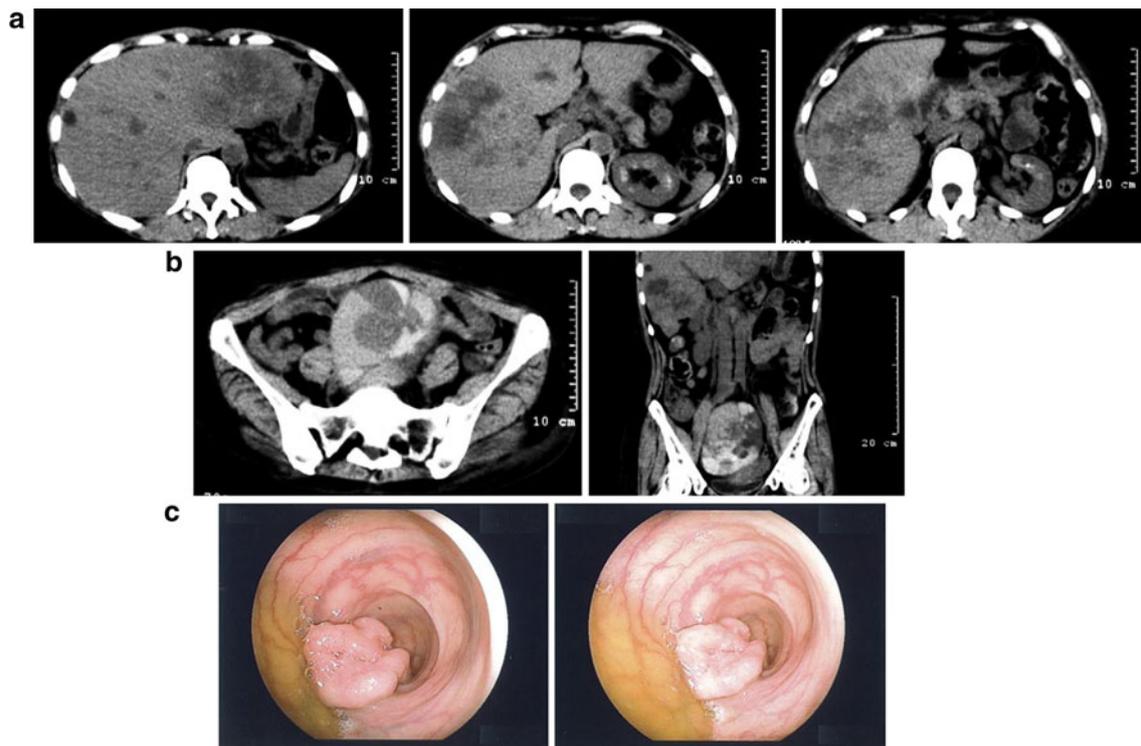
CT images and colonoscopy findings at onset. a Axial images of the liver. Multiple low-density areas suggest metastases. b Axial and coronal images of the pelvic tumor. Various densities ranging
